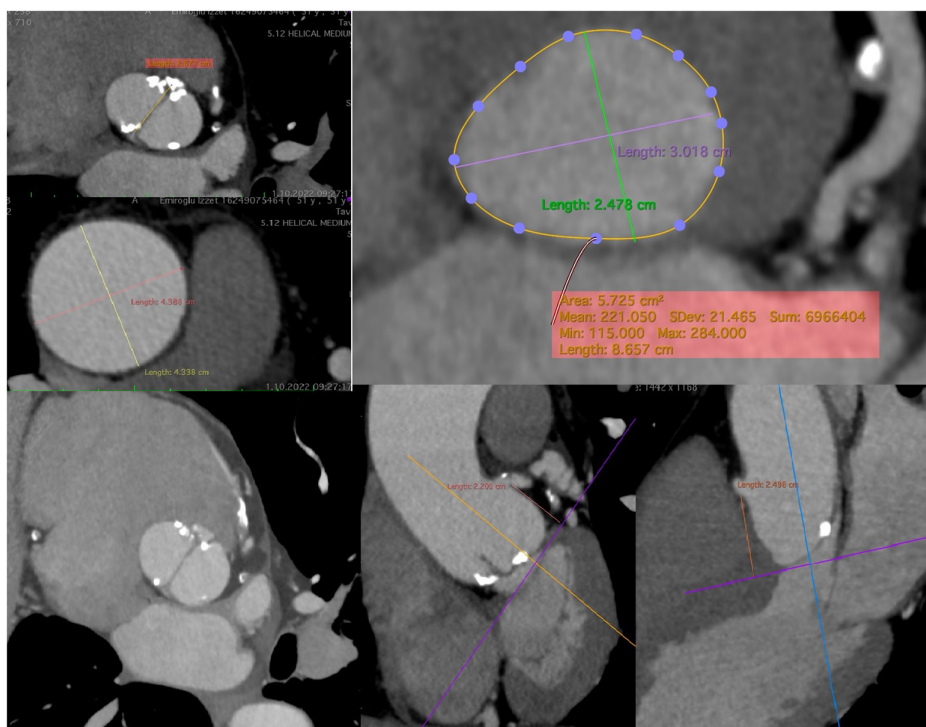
Computed tomography image of the bicuspid aortic valve measurements.
